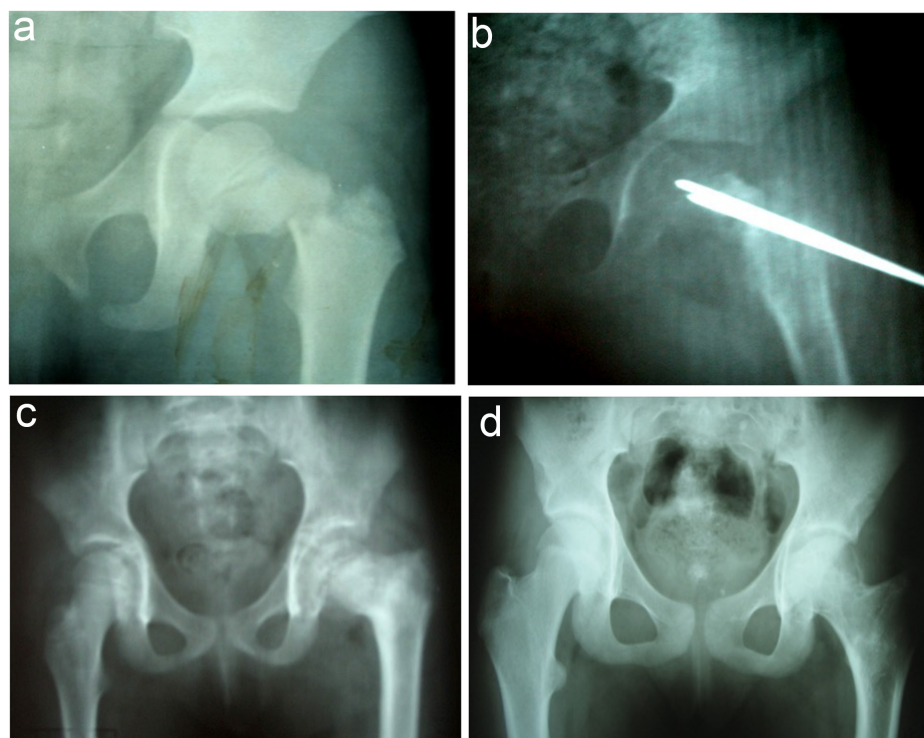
a-d. Radiographs of a 6-year-old girl with a displaced femoral neck fracture, anterior–posterior view (AP) of a Delbet–Colonna type III fracture (a) and AP view after closed reduction and internal fixation with Kirshner wires (b). Postoperative 2-year radiograph demonstrating the coxa vara at the left side of the patient (c) and at skeletal maturity radiograph showing the remodeling of the coxa vara deformity (d).
